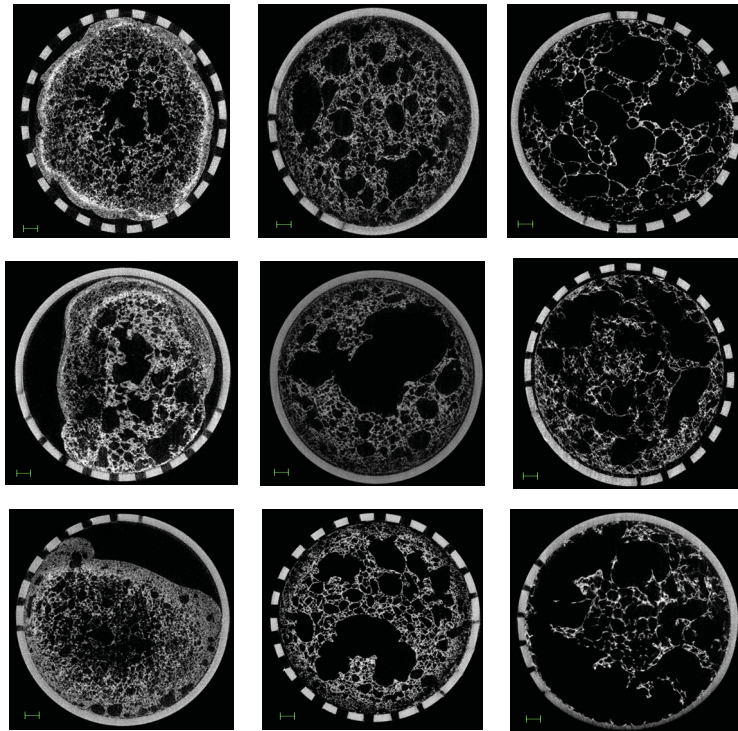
X-ray μ -CT images of DF with PWC 17% (left column, N3 (top), N11 (middle), N15 (bottom)), 21% (middle column, N17 (top), N18 (middle), N19 (bottom)) and 25% (right column, N4 (top), N12 (middle), N16 (bottom)). Scale indicated in green equals 1 mm.
